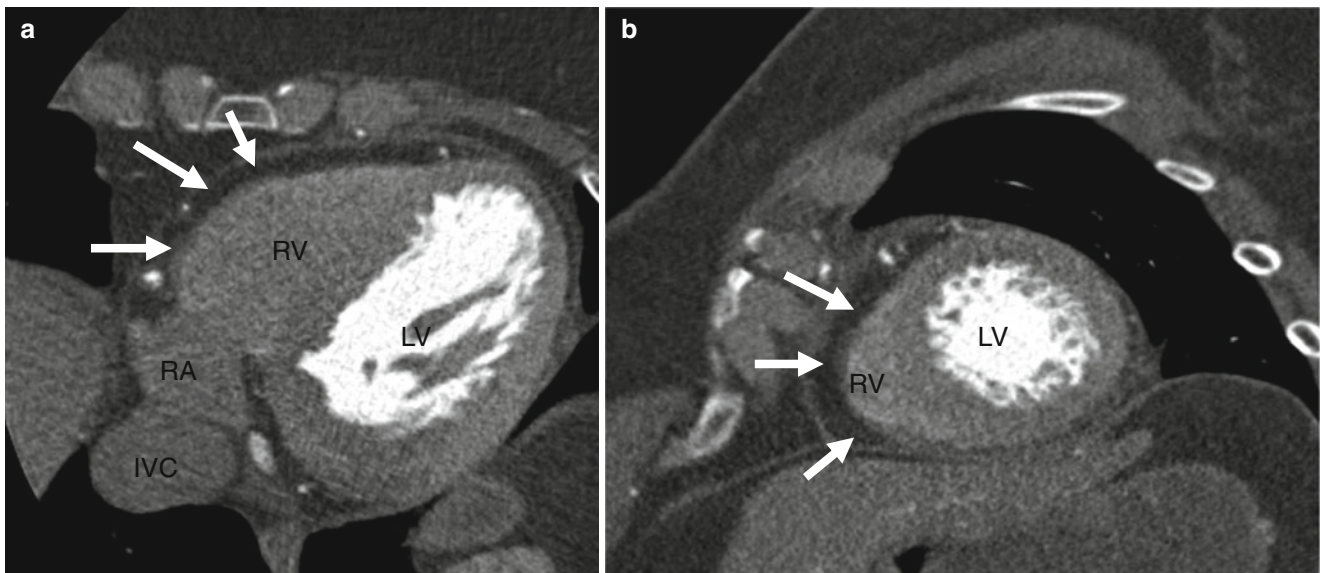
Physiologic myocardial fat in a 70-year-old woman with normal weight for age and without known cardiac disease. Panel (a) axial ontrast-enhanced CT images showing fatty infiltration of the right ventricular (RV) free wall (arrows). Panel (b) short-axis CT image showing
